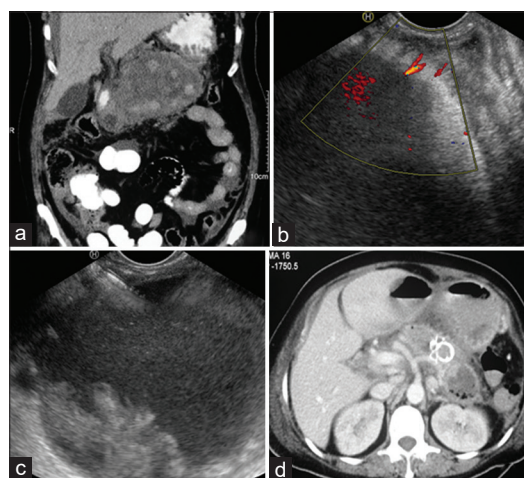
(a) Computed tomography abdomen: Pancreatic fluid collection with hyperdense contents. (b) EUS: small-caliber vessels in the wall of pancreatic fluid collection. (c) EUS-guided drainage of pancreatic fluid collection. Echogenic contents suggestive of blood seen in the collection. (d) Computed tomography abdomen: Resolution of pancreatic fluid collection postlumen-apposing metal stent insertion
